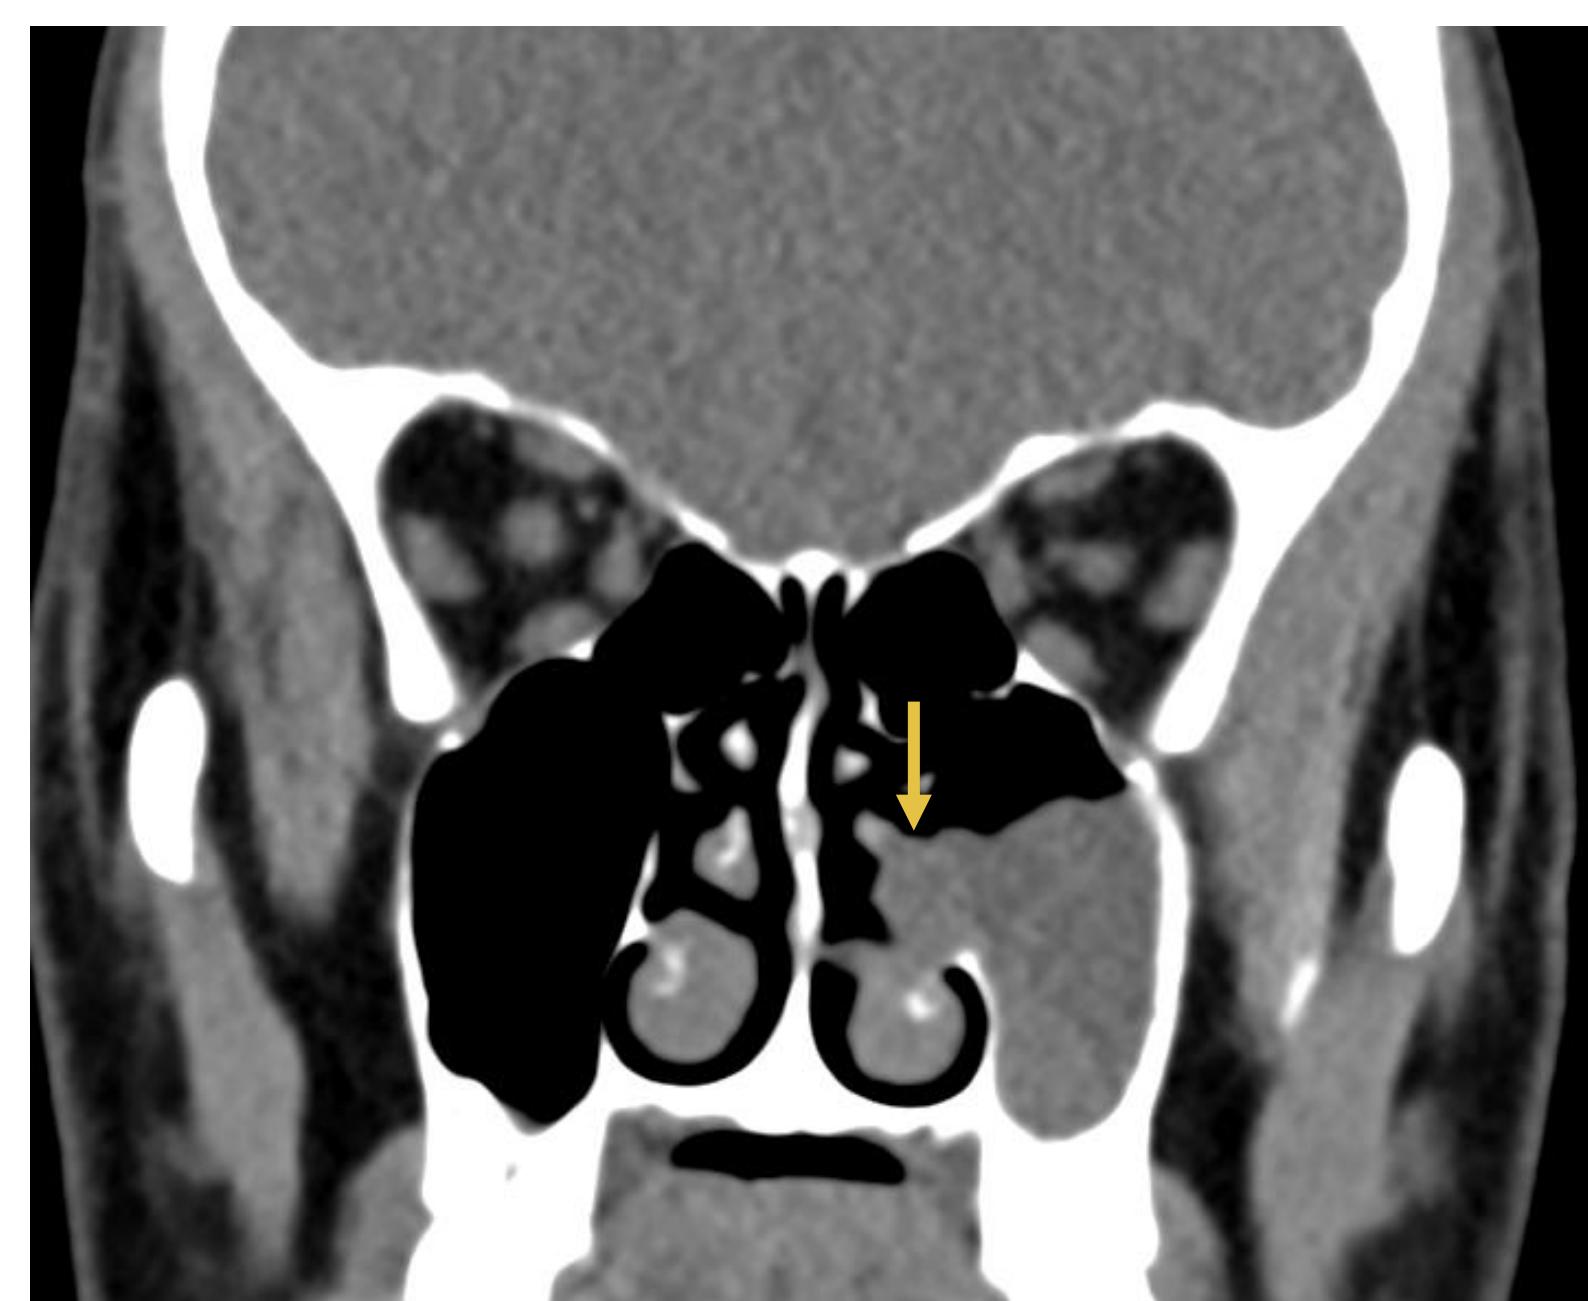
Coronal CT in the soft tissue window confirms the same polypoid mass involving the left maxillary sinus and nasal cavity (arrow), with no osseous stalk identified.
